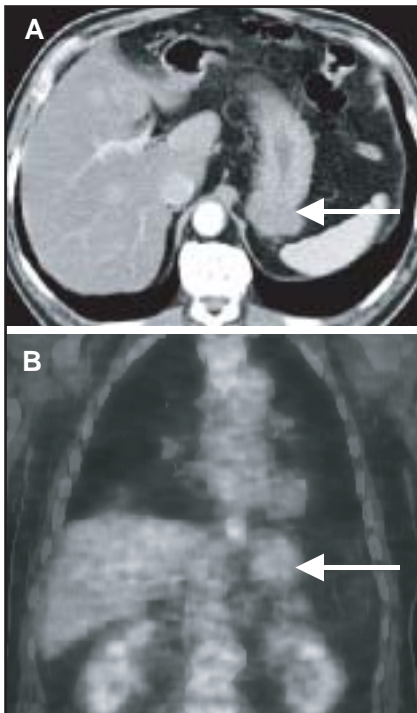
Gastric GIST with negative PET scan. (A) CT demonstrates an exophytic mass with a well-defined margin (arrow) 5 cm in diameter, with homogeneous contrast enhancement. (B) Coronal CT-PET scan shows no uptake of [¹⁸F]FDG tracer in the gastric GIST (arrow).
